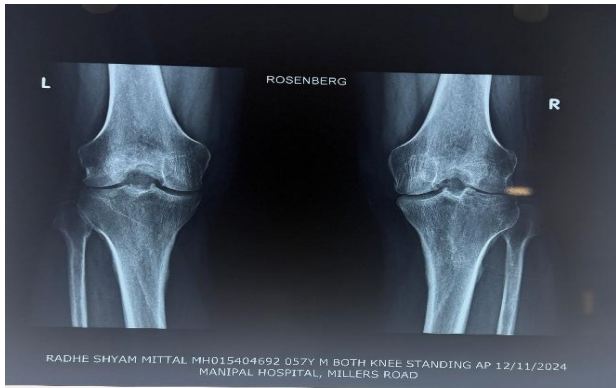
Preoperative standing anteroposterior radiograph (bilateral knees). Radiograph showing bilateral standing AP view of the knees. The left knee demonstrates medial tibiofemoral joint space narrowing and marginal osteophyte formation, consistent with medial compartment osteoarthritis.
